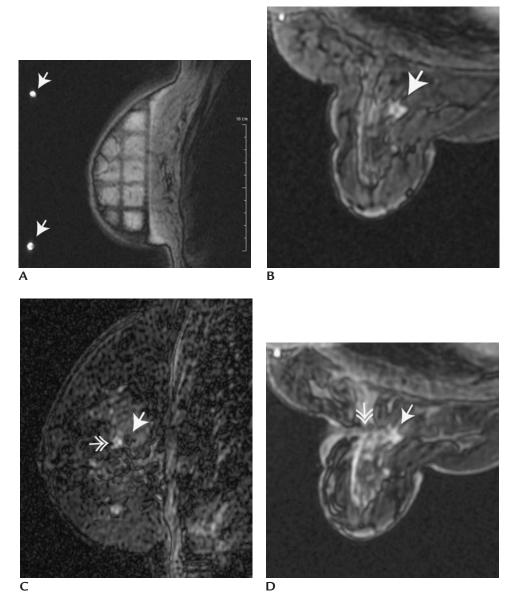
MR-guided breast biopsy. MR detected invasive ductal carcinoma. (A) Sagittal image demonstrating fiducial markers (*arrows*) and impression of fenestrated compression paddle on the lateral aspect of the breast. (B) Axial image demonstrating enhancing lesion (*arrow*) post-contrast and indentations resulting from the compression paddle on the lateral aspect of the breast. (C) Sagittal subtraction image demonstrating void from introducer (*arrow*) and lesion (*double headed arrow*). In this patient, the needle is at the deep margin of the lesion so tissue superficial to the needle will be sampled preferentially. (D) Axial image demonstrating effects of introducer (*double headed arrow*) on tissue and its relationship to the lesion (*arrow*). Since this lesion could not be seen mammographically or sonographically, a clip is placed to mark the location of the lesion (post clip placement images are not shown) following the MRguided biopsy.
